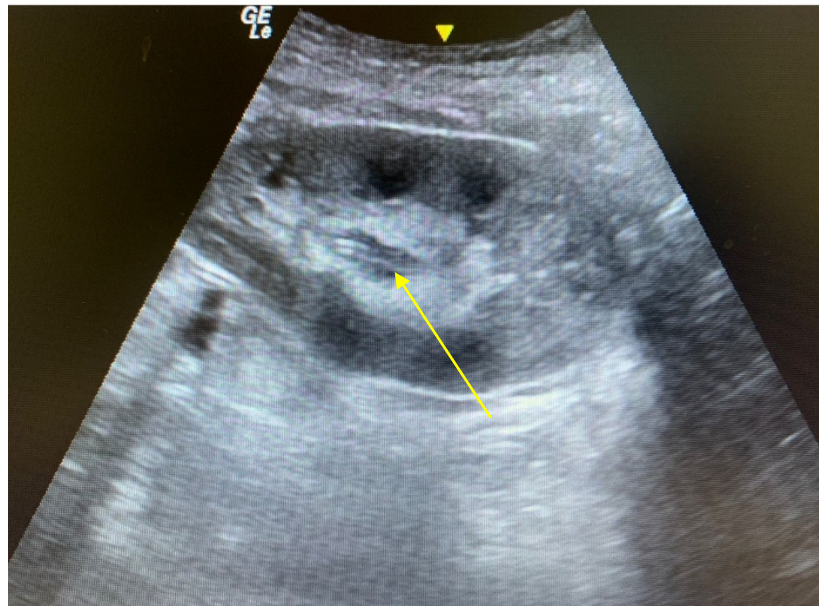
Ultrasonogram of the renal graft after ureteral stent implantation (the stent is located in the renal pelvis) (yellow arrow)
